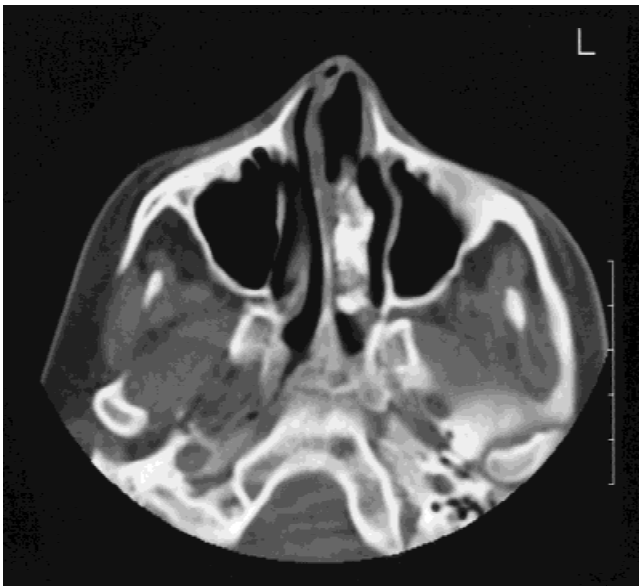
CT scan of the sinuses of Case 2, showing a tumor mass extending from the anterior nasal region with a protrusion to the posterior side.
